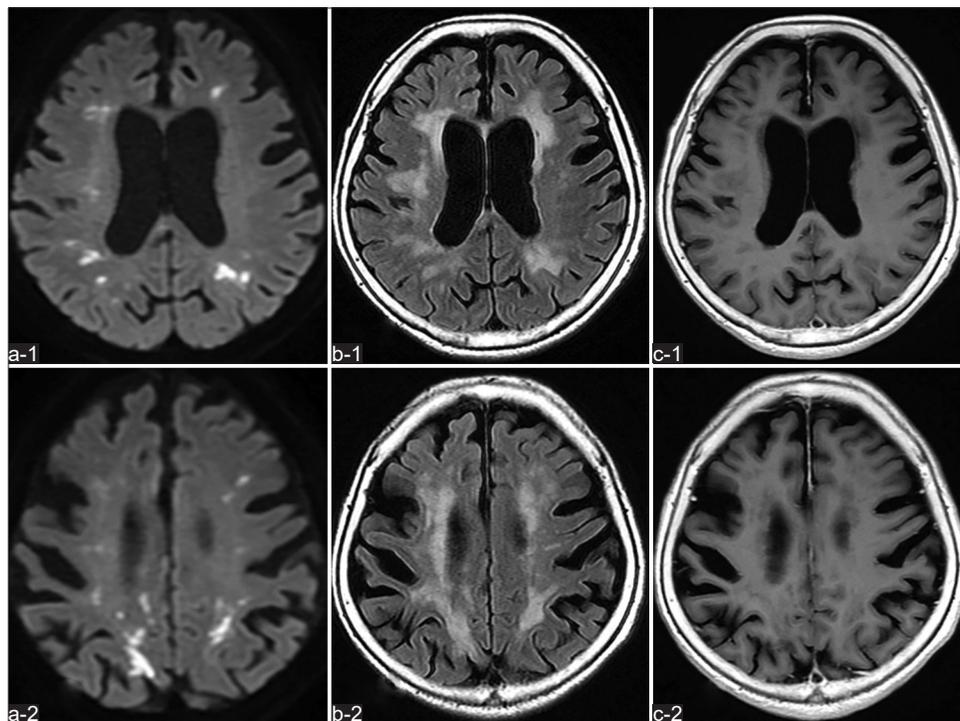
Magnetic resonance imaging findings of the brain. Axial diffusion-weighted imaging (a-1 - a-2) and fluid-attenuated inversion recovery imaging (b-1 - b-2) obtained at admission reveal multiple hyperintense lesions bilaterally in the periventricular white matter, centrum semiovale, and corpus callosum. T1-weighted imaging (c-1 - c-2) acquired after injection of gadolinium contrast medium shows no enhancement of the lesions.
